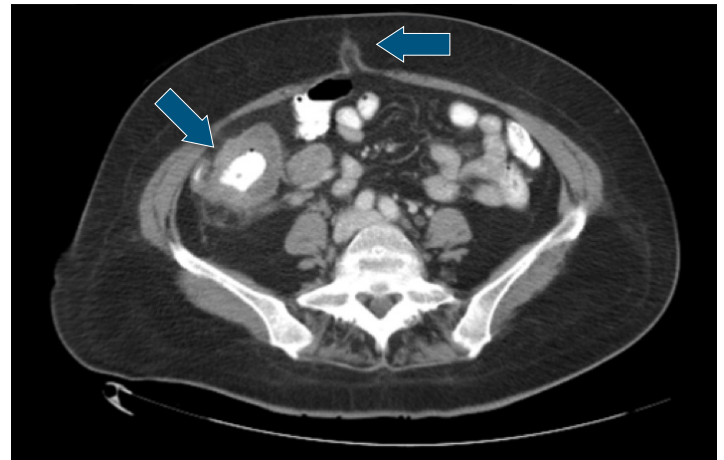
CT scan demonstrating colon cancer (left arrow) and ventral hernia (right arrow).
